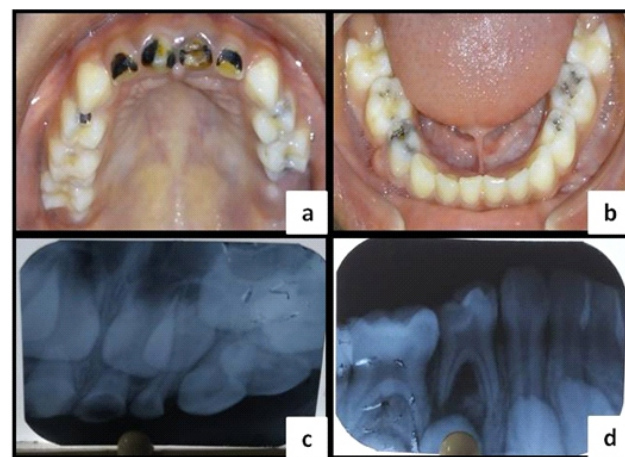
a) Maxillary arch view showing dental caries wrt. 54, 64, 65 and grossly decayed teeth wrt. 51 52 61 62; b) Mandibular arch view showing dental caries wrt. 75, 74, 85 and deep dental caries & intraoral swelling wrt. 84; c) Preoperative radiograph showing radiolucency involving pulp wrt.61; d) Preoperative radiograph showing radiolucency involving pulp wrt 84
